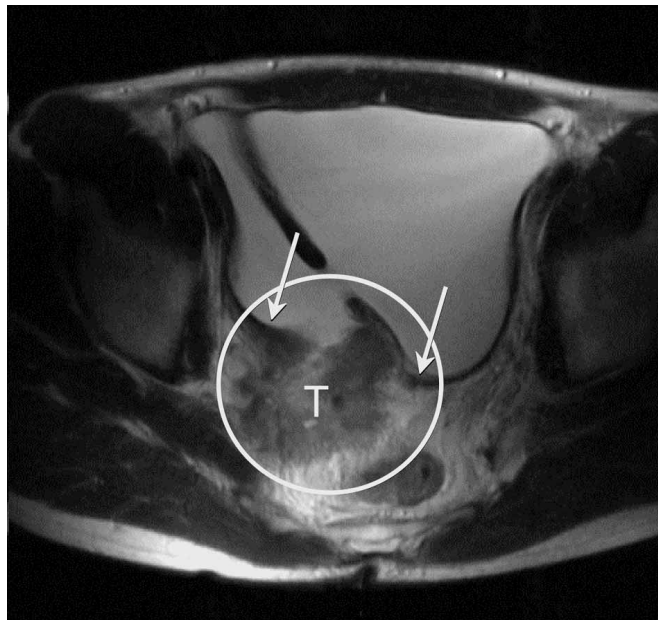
Same patient as Fig. 1. On axial high-resolution T2-weighted MR images, disruption of the normal low signal intensity bladder wall is present (*arrows*), which argues for at least deep muscular invasion of the wall. Also there is invasion in the perivesical fat
